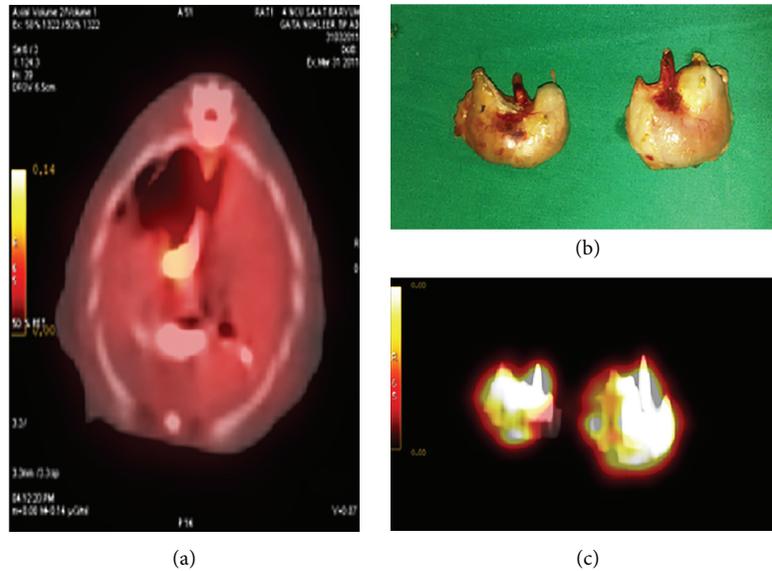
PET/CT image demonstrated the presence of the activity that can be interpreted as to be the activity of the labeled stem cells in the lower portion of the esophagus containing barium sulphate (a). Esophagogastric junction was resected (b) and imaged (c) by PET/CT to delineate the prominent activity in the lower portion of the injured esophagus.
